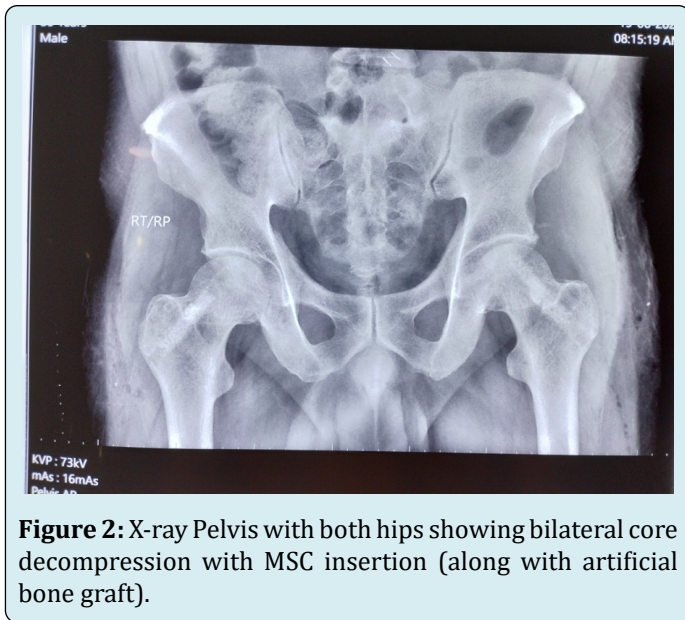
X-ray Pelvis with both hips showing bilateral core decompression with MSC insertion (along with artificial bone graft).
